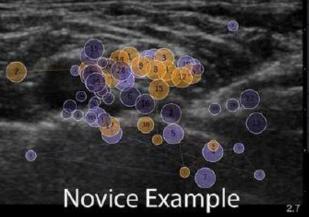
Eye gaze fixations and attention overlaid on actual real-life view of ultrasound machine.
